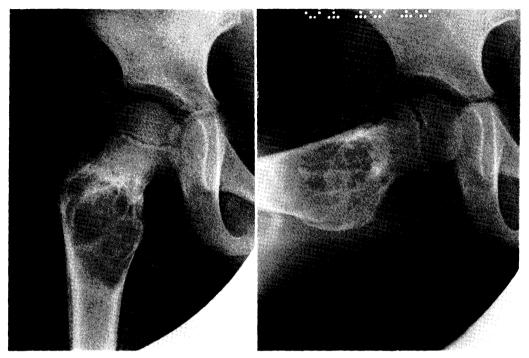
Preoperative radiograph, 5 years old.
